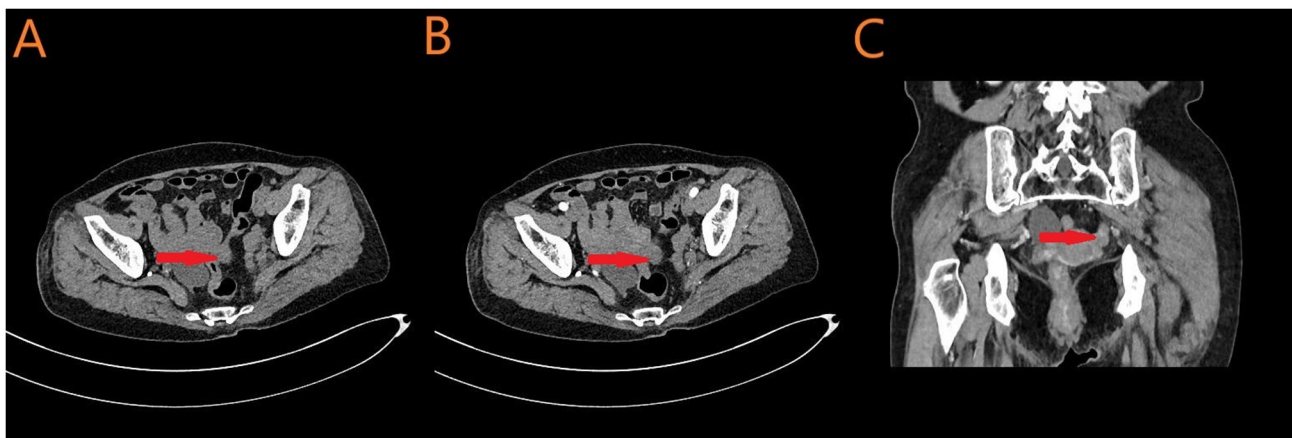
Pelvic CT images. (A) Plain phase, (B) arterial phase and (C) coronal images.
